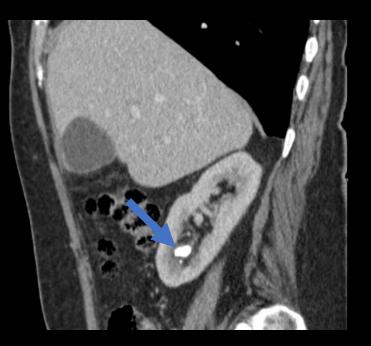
Coronal and Axial CT scans. Nephrolithiasis.
